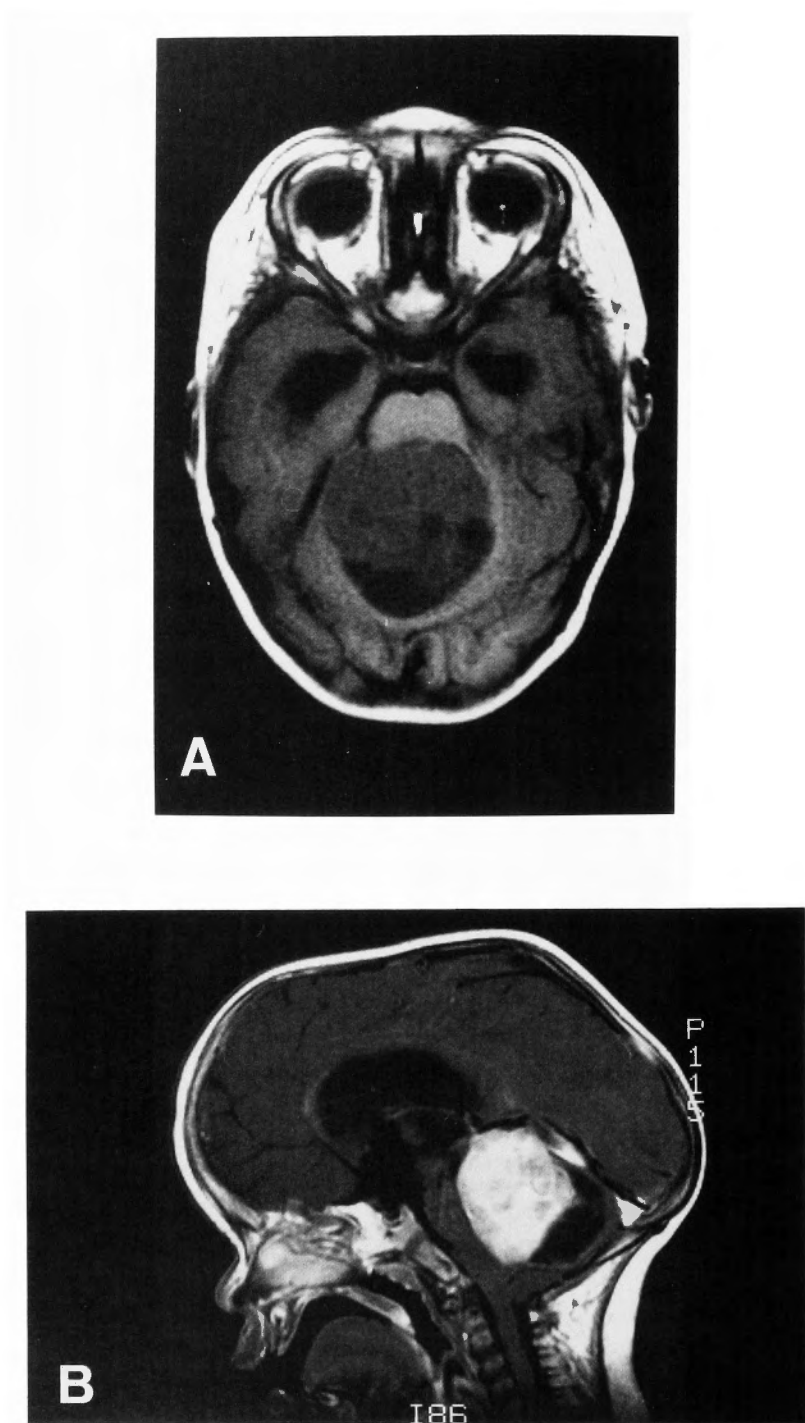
MRI shows a large midcerebellar mass with low intensity on T1 weighted image (A) and marked enhancement by gadolinium-DTPA (B).
